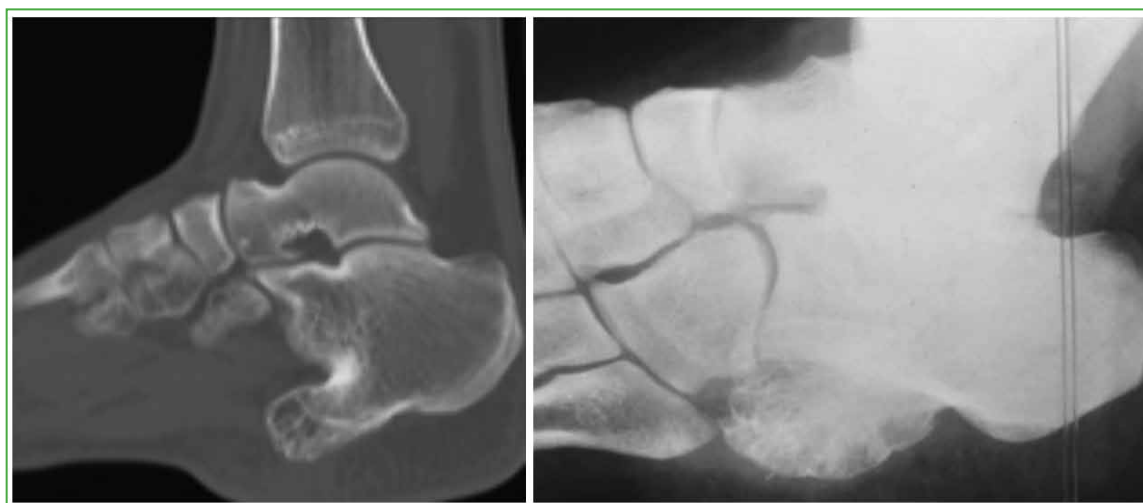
Preoperative foot radiograph, lateral view. A large, pedunculated tumor with clear borders is observed, emerging from the plantar base of the calcaneus.
